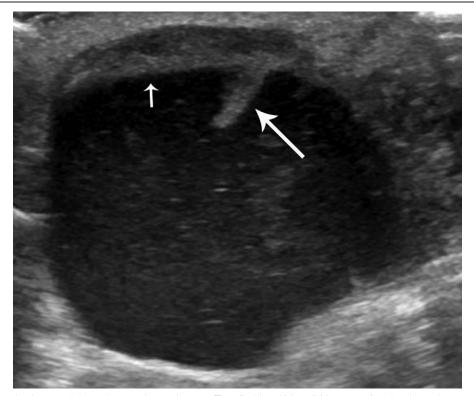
B-mode ultrasound showed a complex cystic mass (Type I) with a thick wall (short arrow) and an internal septum (long arrow).
